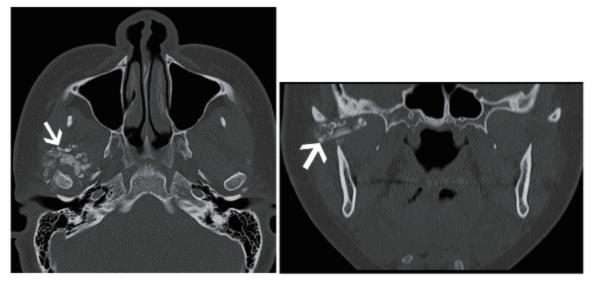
CT-scan image showing calcification of the lesion in the axial and coronal planes. (Arrows)
